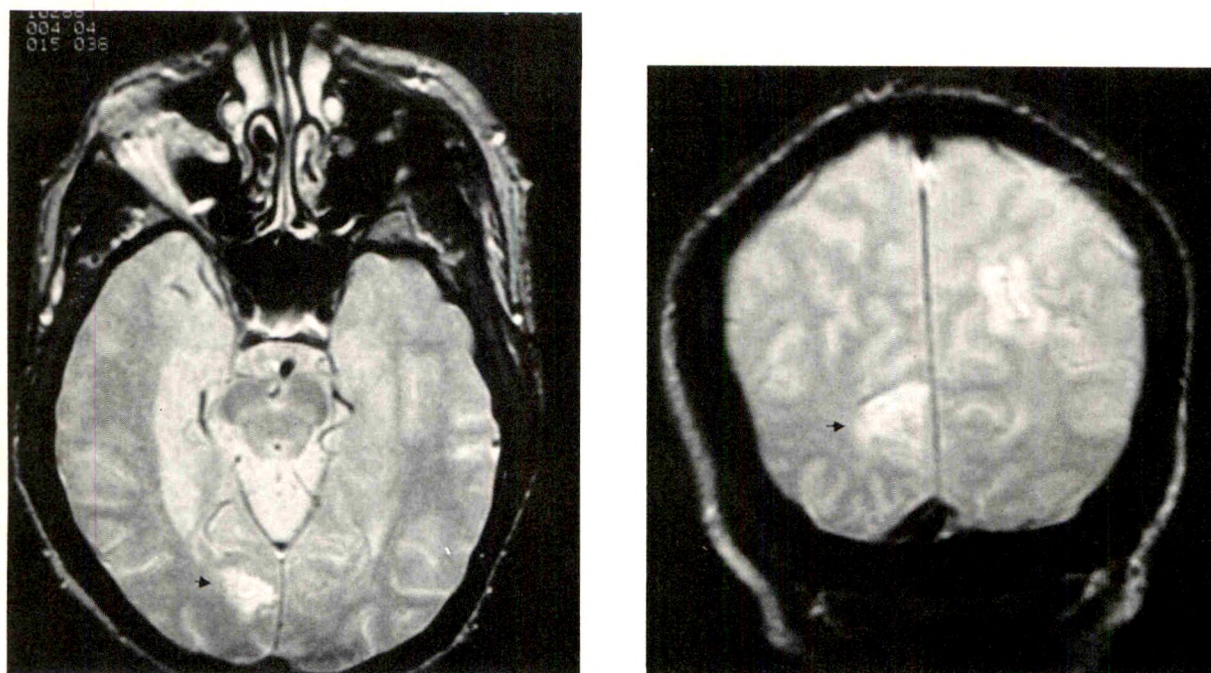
(Grossman and associates). High signal intensity in the right occipital lobe in the region of the calcarine fissure, indicated by the arrows, demonstrated by axial (left) and coronal (right) magnetic resonance imaging utilizing parameters of repetition time = 3,000 msec, echo time = 90 msec, number of excitations = 1.
